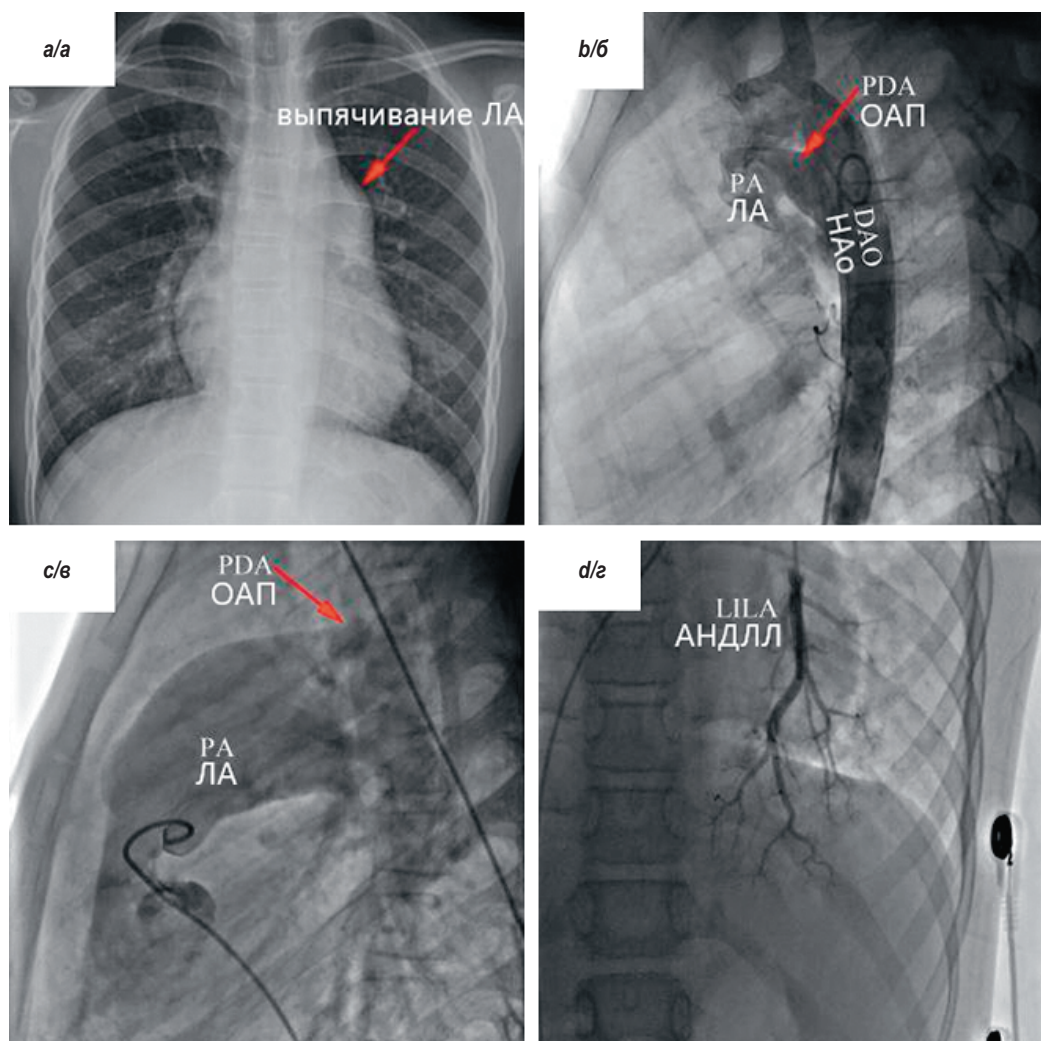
A clinical case of pulmonary hypertension in combination with an open ductus arteriosus: *a* — on chest X-ray, an arrow indicates a bulge of the pulmonary artery at the upper left border of the heart (cardiac shadow); *b* — Descending aortography revealed a large PDA; *c* and *d* — pulmonary arteriography showed a large PDA and decreased pulmonary capillary filling. LILA — left inferior lobe artery; PA — pulmonary artery; DAO — descending aorta; PDA — patent ductus arteriosus [31]
